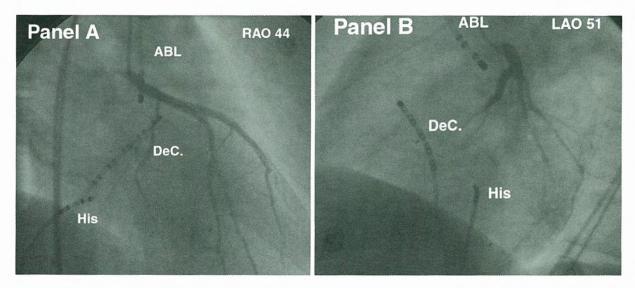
Radiographic localization of the ablation catheter at successful site in the Valsalva of the left coronary cusp and its relationship with the left main coronary artery in RAO 44° (Panel A) and in LAO 51° (Panel B) positions. ABL = ablation catheter, DeC. = decapolar catheter, His = His catheter.
